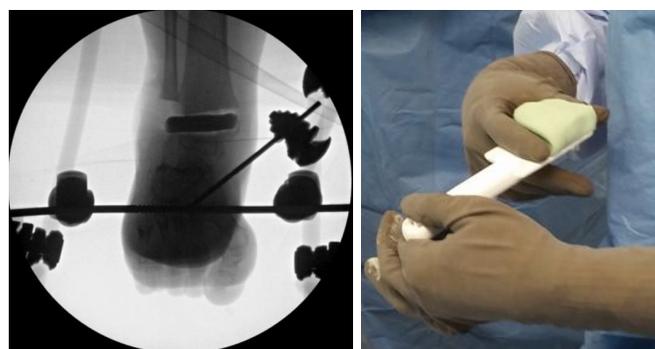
Intra-op radiographs and picture of Vancomycin PMMA spacer.
